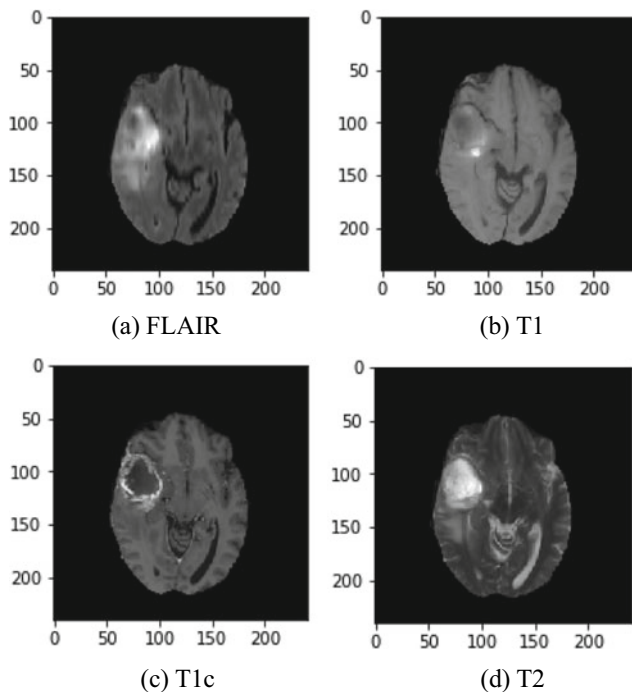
Four MRI modalities in imaging data from HGG patient 0001
